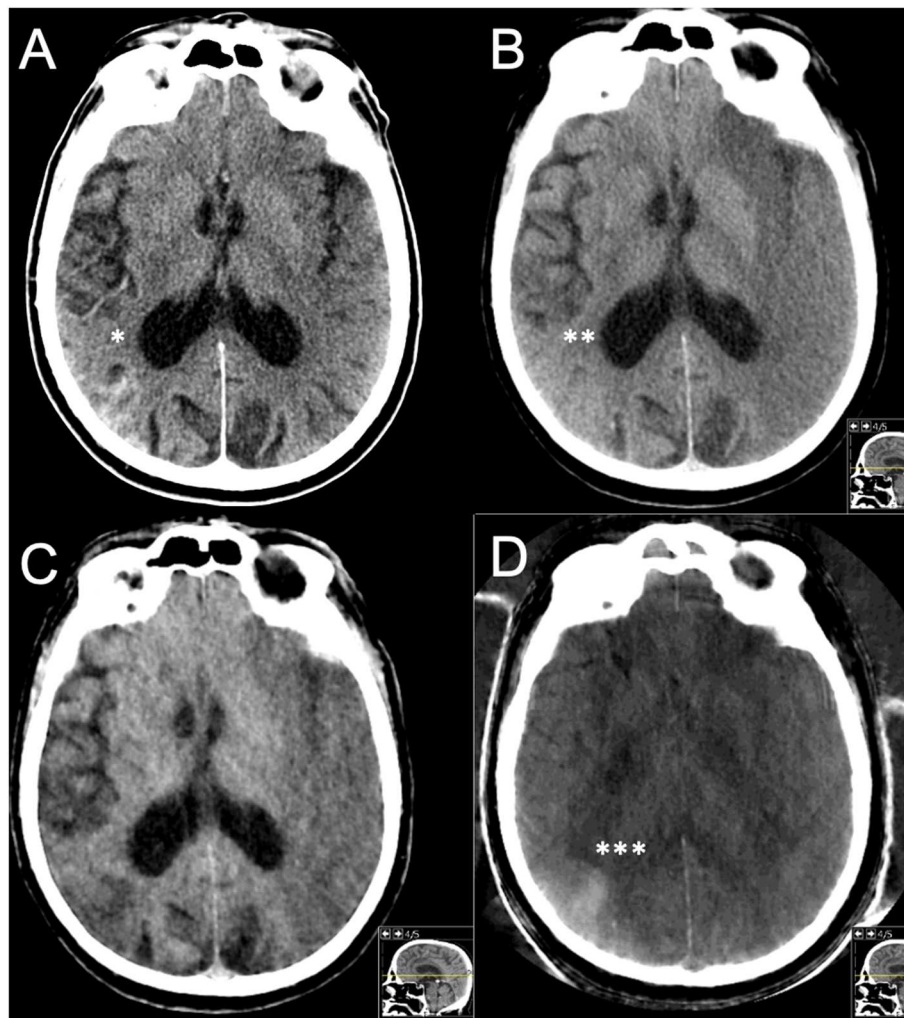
Case example. Male, 72 years old, with hypertension. Right-sided hemiparesis with NIHSS 24 points at stroke onset and a left-sided M1 occlusion and a (missed) very subtle infarction with ASPECT 3. Routine drip-and-ship from a primary stroke center following IVT initiation to a thrombectomy center. IVT was stopped due to clinical worsening before arrival. The repeated stroke imaging there showed extensive manifest infarction (ASPECT 3) on the left side but also a hemorrhage within an infarct on the right side. Rejected for thrombectomy. (A) SECT 1 h 15 min after IVT initiation with signs of hemorrhage*. (B) pCT, (C) wDECT, and (D) iDECT, all at 10 h, on pCT alone judged to be a HI2 bleeding; however, wDECT and iDECT showed iodine* within an infarct, originating from an IV contrast injection for a CTA done immediately prior to initial IVT administration. Clinical workup showed a previously undiagnosed atrial fibrillation, with cardioembolism deemed to be the likely cause of stroke.
